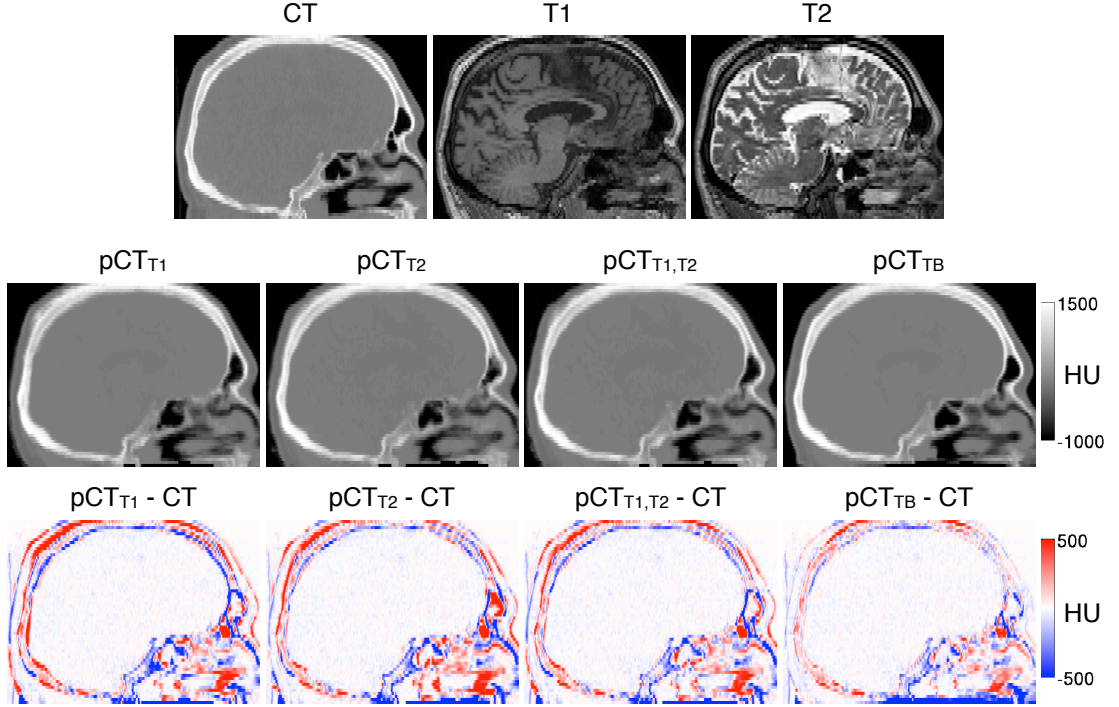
Example for a representative subject of the reference CT, T1 and T2 images (top), the different pseudo CTs (middle), and the difference images between the pseudo CTs and the reference CT (bottom).
